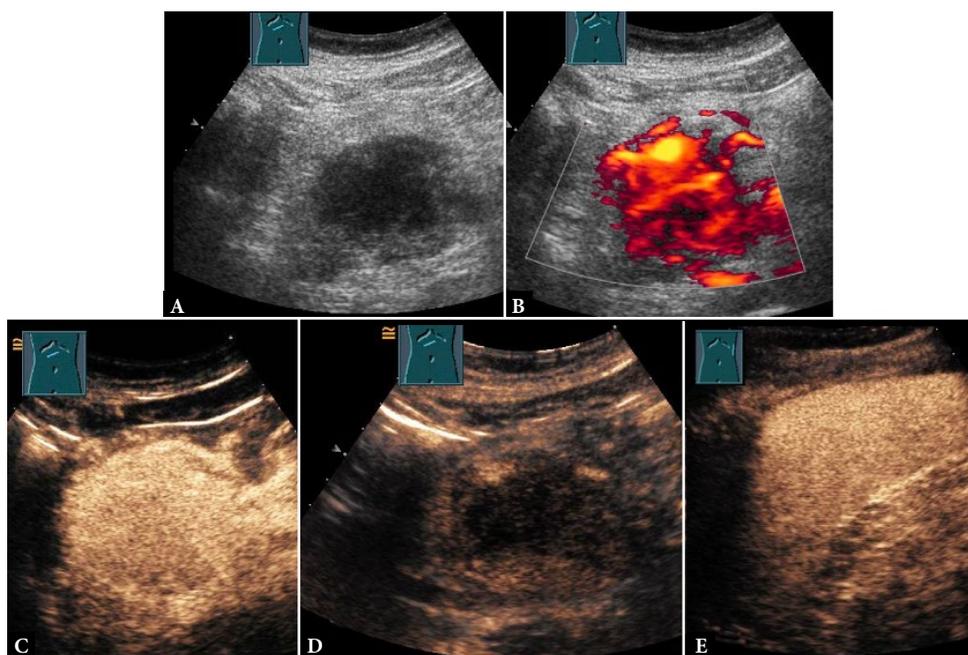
Pancreatic plasmacytoma manifestation with a hypoechoic tumor lesion on B-US (A) and strong flow signals on color Doppler sonography (B). On CEUS, the lesion demonstrates arterial hyperenhancement (C) followed by parenchymal hypoenhancement (D), compared to the enhancement of the spleen as an in-vivo reference (E)
